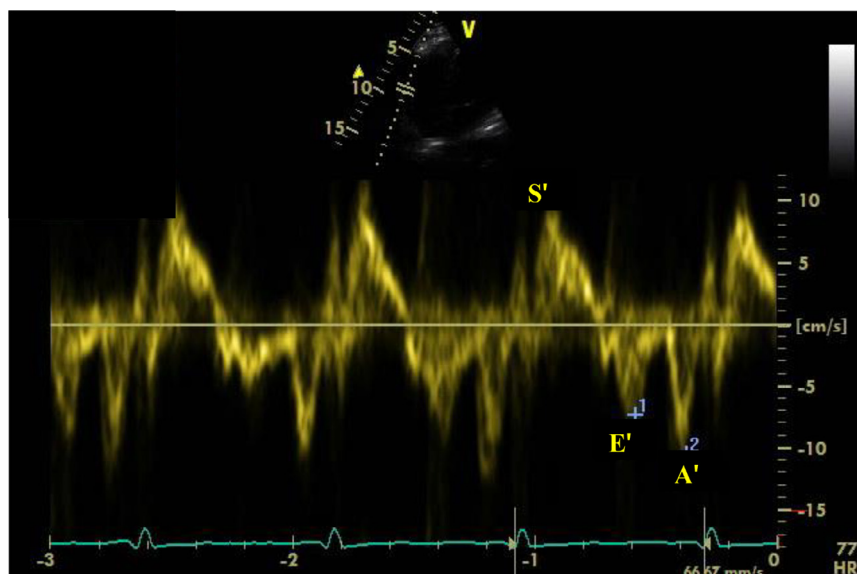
Tricuspid annulus lateral velocity using pulse wave tissue Doppler in apical 4 chamber view.
